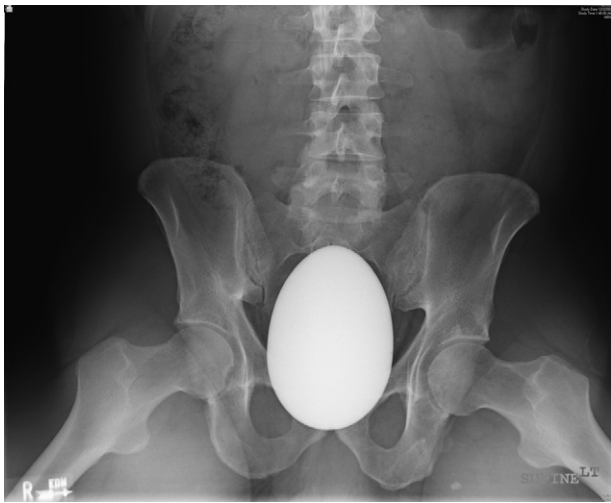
Pelvic X-ray of the foreign body in situ.
